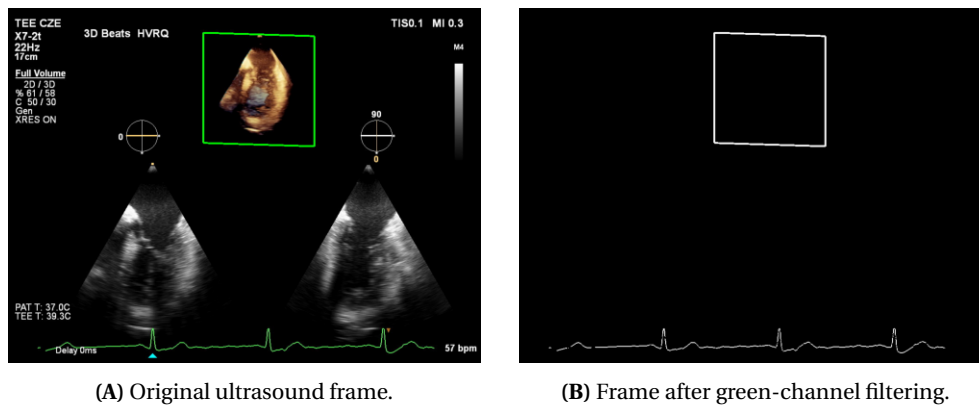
Example of a green 3D box in ultrasound imaging and its effect after applying green filtering.
